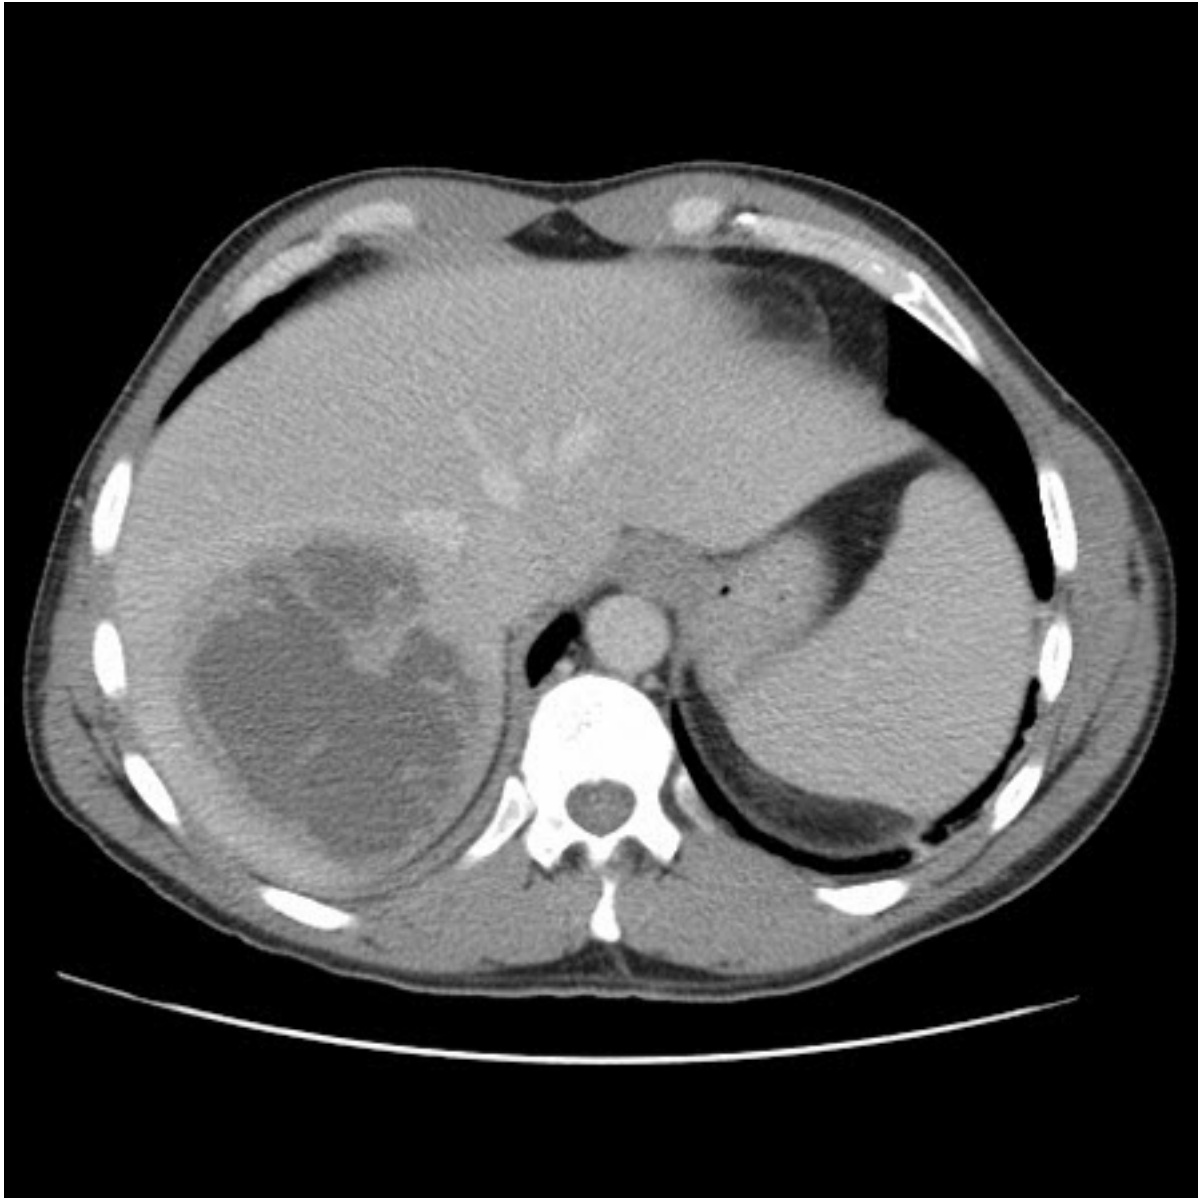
Liver abscess: CT scan (axial view) showing liver abscess in a 46-year-old man who presented with fever, fatigue, and cough
